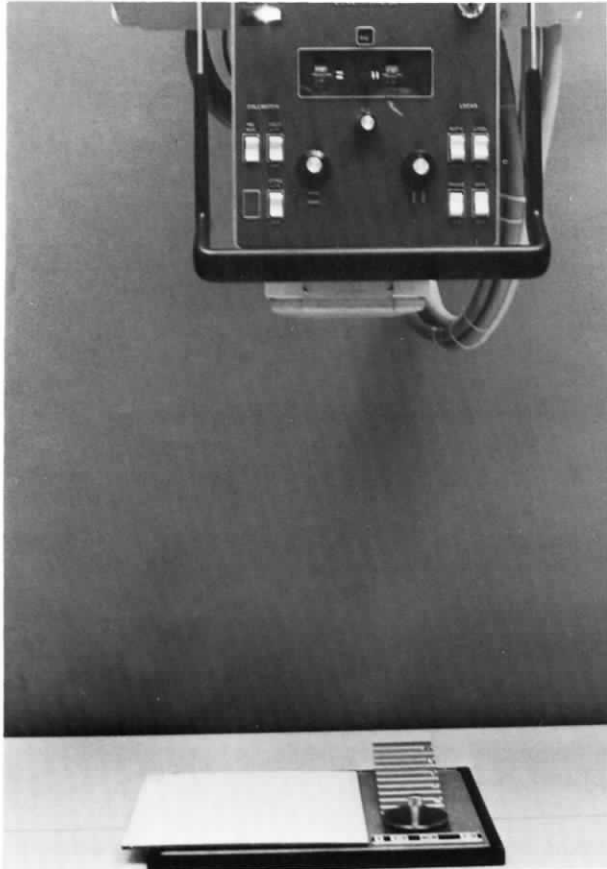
Generator linearity test setup. The step wedge should be placed directly under the central beam, and the remainder of the cassette covered with at least  $\frac{1}{8}$  inch (3 mm) of lead. Note that this step wedge also contains a spinning top for checking the timing of single-phase generators. Room identification and date information must be included on the radiograph.
